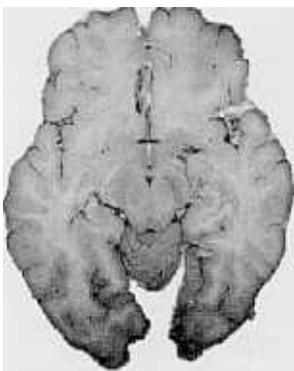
Real image (left), segmented image (middle), and MRI (right) of the brain.
